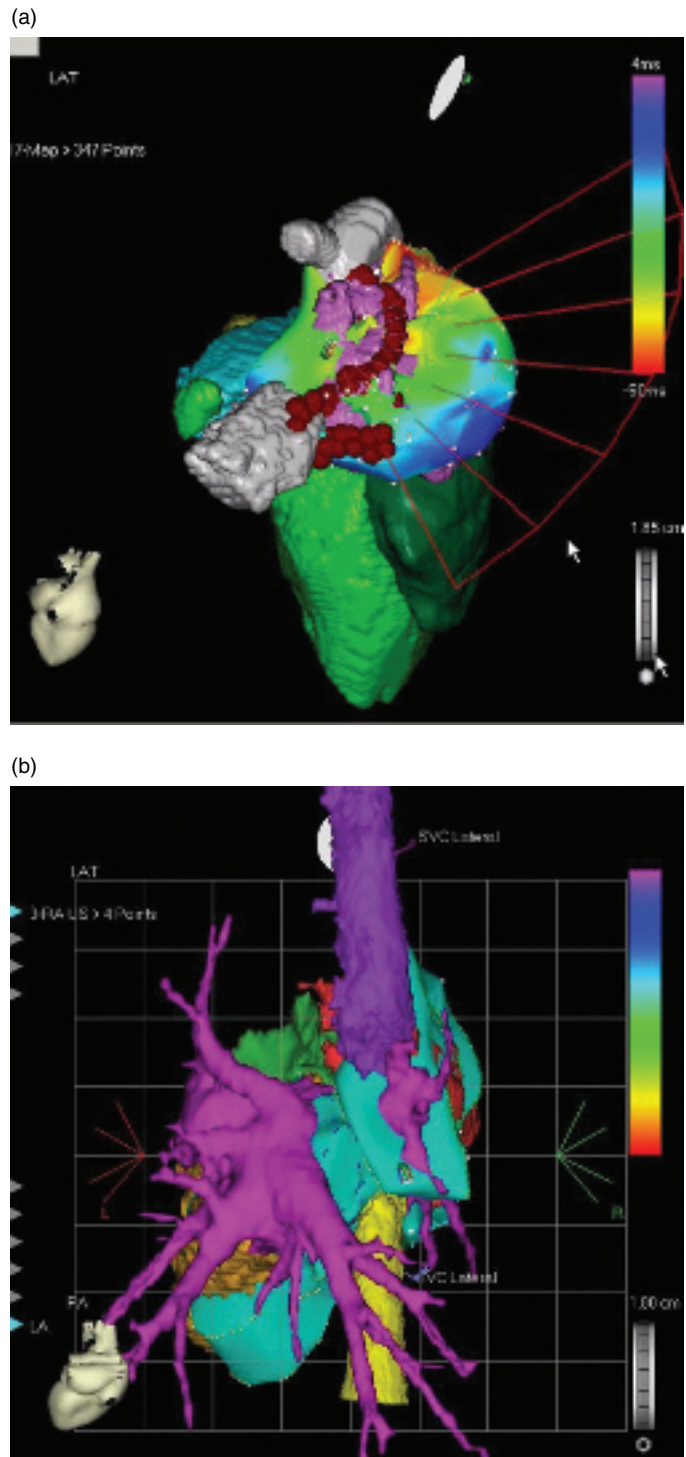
Enabling multimodality fusion: (a) An ultrasound-based cardiac reconstruction of a canine heart. All four chambers were reconstructed from real-time locatable ICE catheter (CartoSound) images. The fan depicts the orientation of the real-time ultrasound beam. The RA was then electrically mapped (LAT shown) and an ablation line was carried out. (b) An imported preacquired image (CartoMerge), segmented LA with the pulmonary veins, was fused on to a registered real-time ultrasound-based reconstruction.
